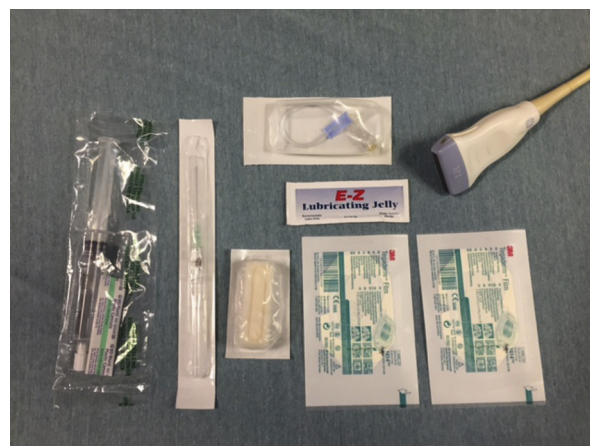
Materials needed for insertion of an internal jugular (IJ) vein catheter (the Easy IJ technique) and step-by-step instructions. The technique requires an ultrasound machine with a high-frequency linear transducer, chlorhexidine, a 4.8-cm, 18-gauge single-lumen catheter, two bio-occlusive adherent dressings, sterile ultrasound gel media, a loop catheter extension, and a saline flush.
